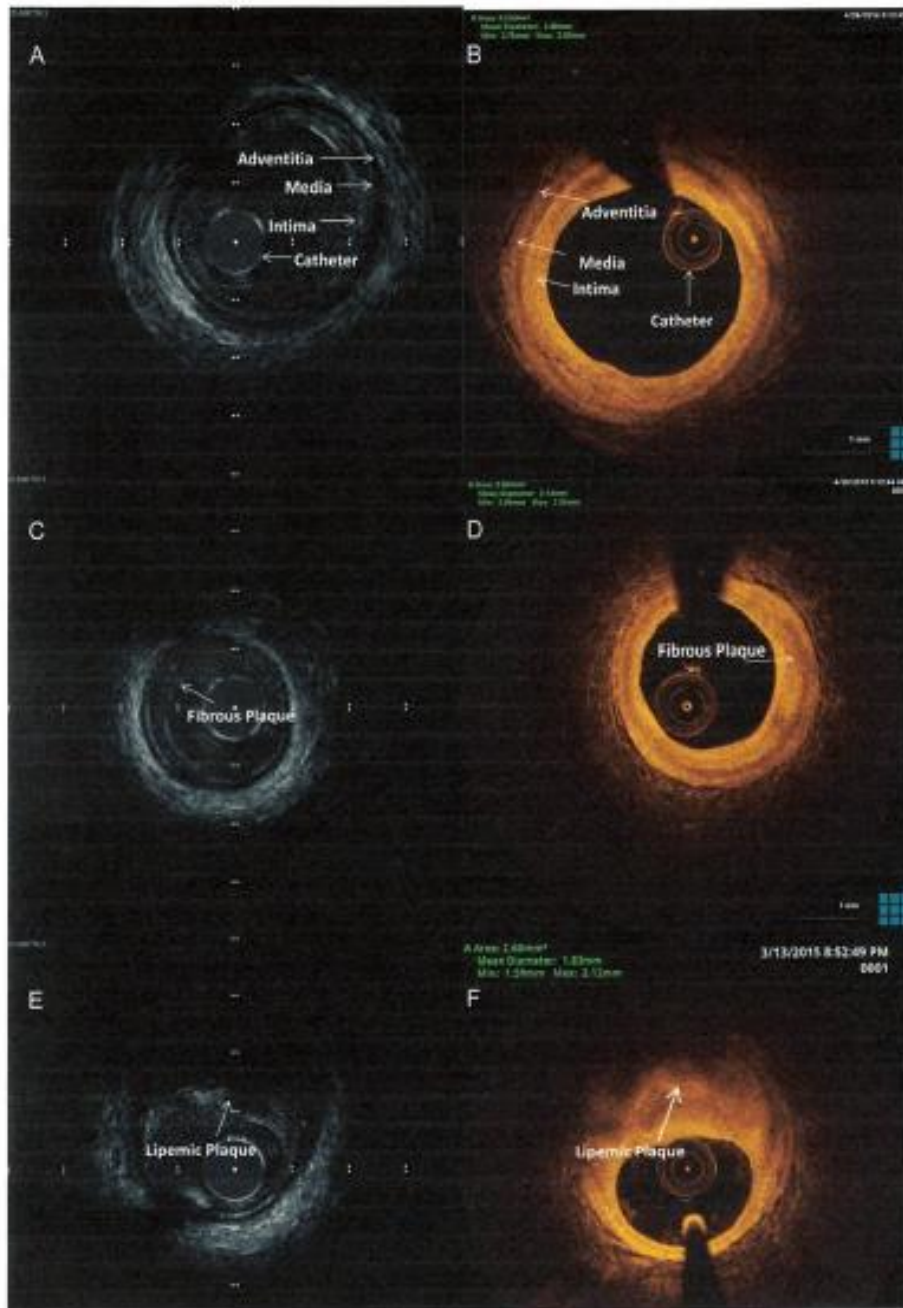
Various plaque morphologies as seen by intravascular ultrasound (IVUS) (left) and optical coherence tomography (OCT) (right). (A and B) Normal characteristics of the vessel wall. (C and D) Eccentric fibrotic plaque. (E and F) Lipid plaque. The lipid component of the plaque is echolucent (IVUS) and also appears as a low signal (low light reflection, OCT). (G and H) Calcium creates a deep acoustic shadowing that hides the underlying structures (asterisk) and hampers the delineation of the external elastic membrane. The posterior boundary of the calcium deposit (asterisk) appears sharp and well visible with OCT (H). (I and J) Stented segments.
